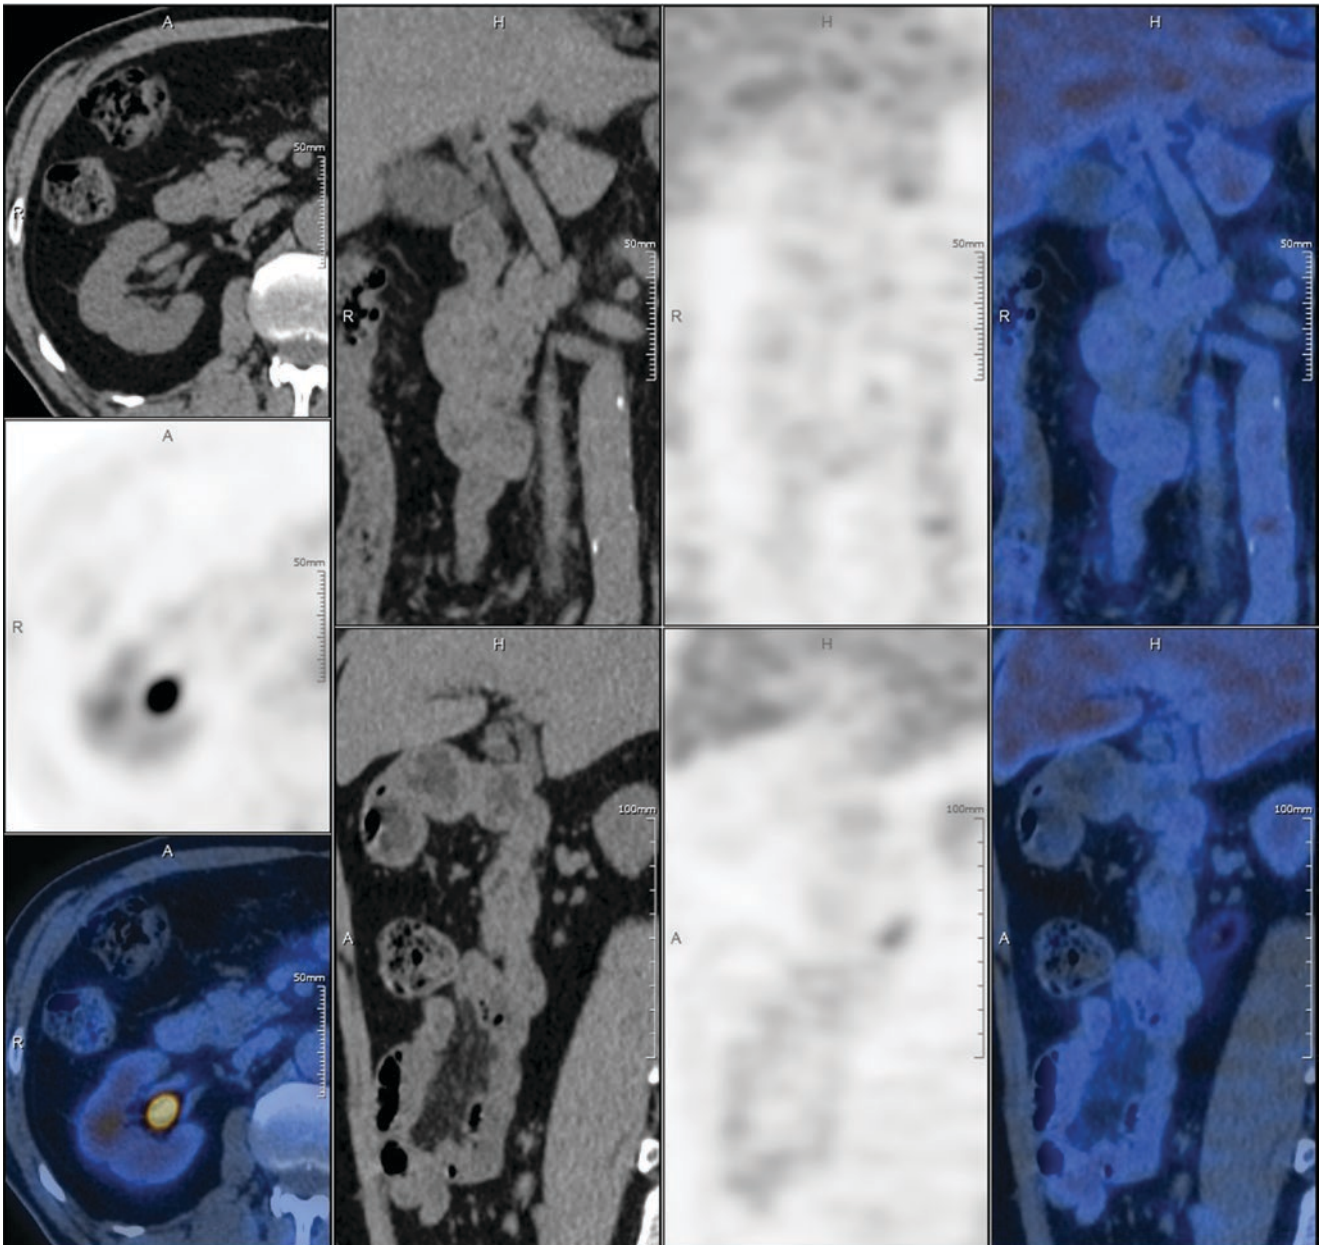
Complete morphologic and metabolic responses of the myeloid sarcoma in the descending part of the duodenum. The follow-up PET/CT scan demonstrates disappearance of the mass in the descending part of the duodenum
